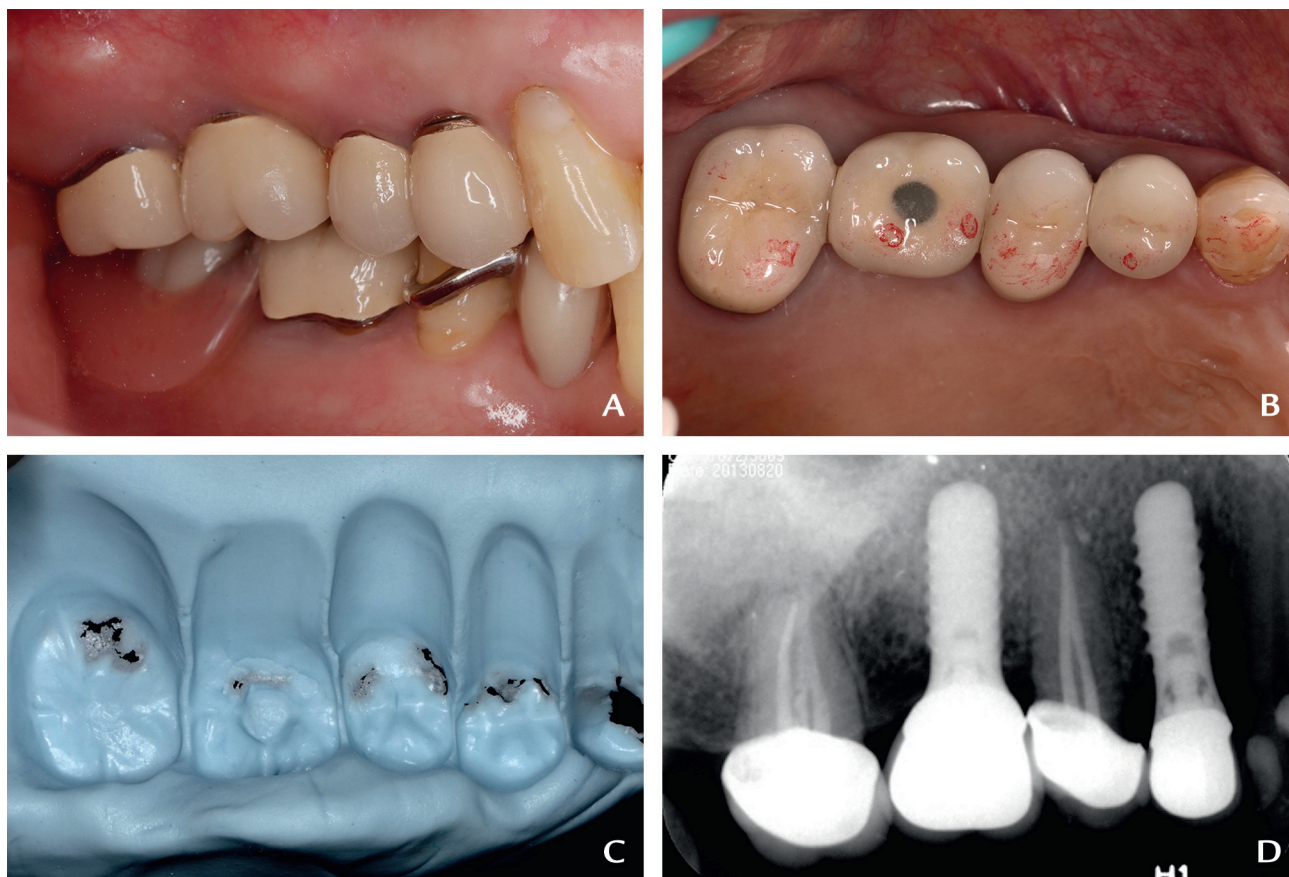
Complete reversal of intruded maxillary right second premolar 6 months after correcting proximal contact. A, Buccal view. B, Occlusal view. C, Silicone occlusal registration. D, Periapical radiograph.
